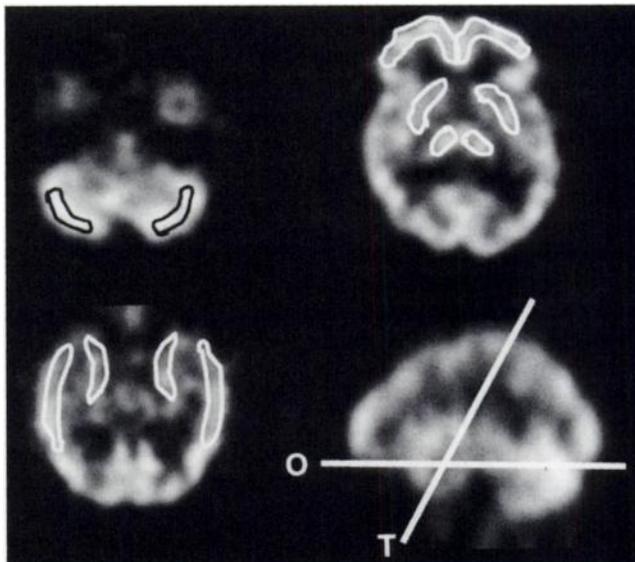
Representative template of ROIs used to obtain region-to-cerebellum SPECT ratios. ROIs corresponding to cerebellum, orbitofrontal and prefrontal cortex, basal ganglia, and thalamus were placed on orbitofrontal slices (O). ROIs corresponding to mesial and lateral temporal regions were placed on temporal slices (T).
